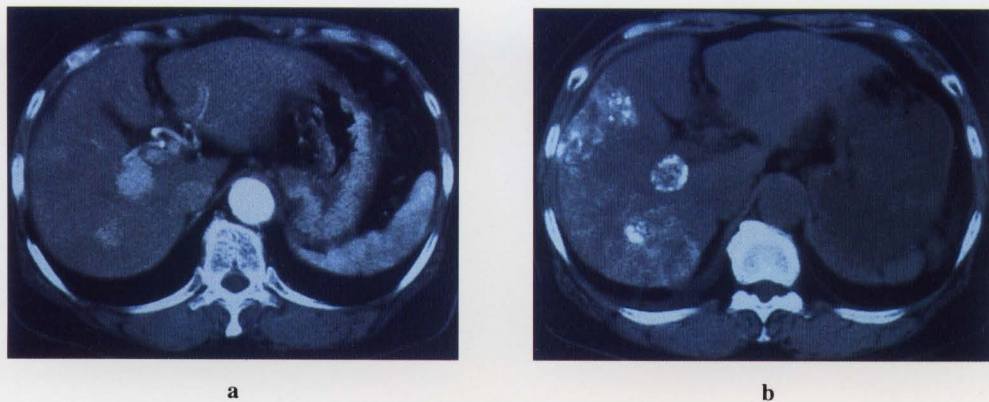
Abdominal CT images of the same patient with Figure 1. (a) Dynamic study in early phase before chemolipiodolization. Multiple early enhancements are observed in the right lobe. (b) Lipiodol CT, 7 days after chemolipiodolization. There are accumulation of lipiodol in the right lobe. There are no apparent changes of the hepatic size and shape.
